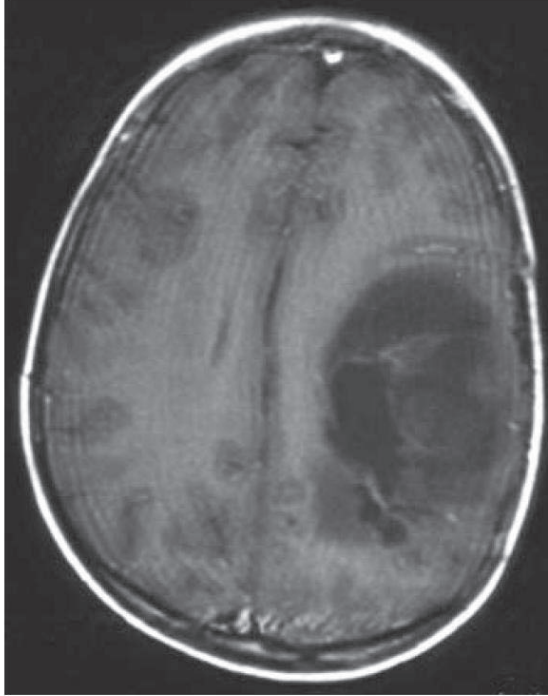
Pre-operative MRI scan showing a recurrent tumour in the left temporo-parietal lobe.
